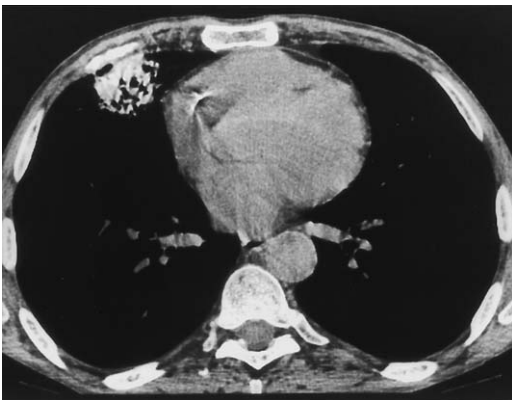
Amiodarone toxicity in a 69-year-old man. Non-contrast axial CT shows a focal area of high attenuation consolidation in the anterior right midlung, consistent with amiodarone.
